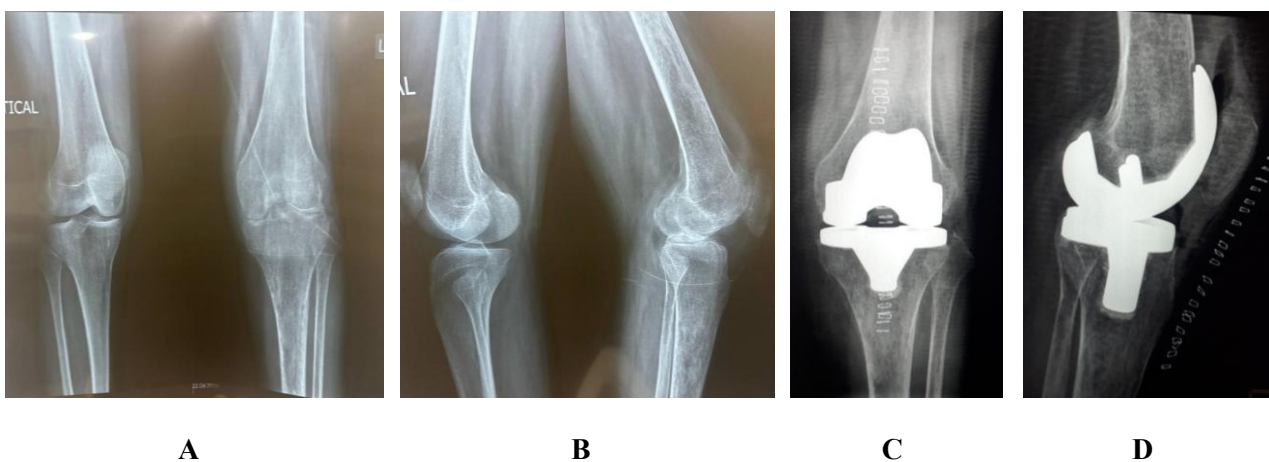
(A-D). Preoperative anteroposterior and lateral radiographs demonstrating advanced rheumatoid arthritis with symmetrical joint space narrowing, marginal erosions, periarticular osteopenia, and deformity of the distal femur and proximal tibia (A–B). Postoperative radiographs following cemented total knee arthroplasty (C–D) show well-positioned femoral and tibial components with restoration of limb alignment, correction of joint deformity, and appropriate interface fixation.
